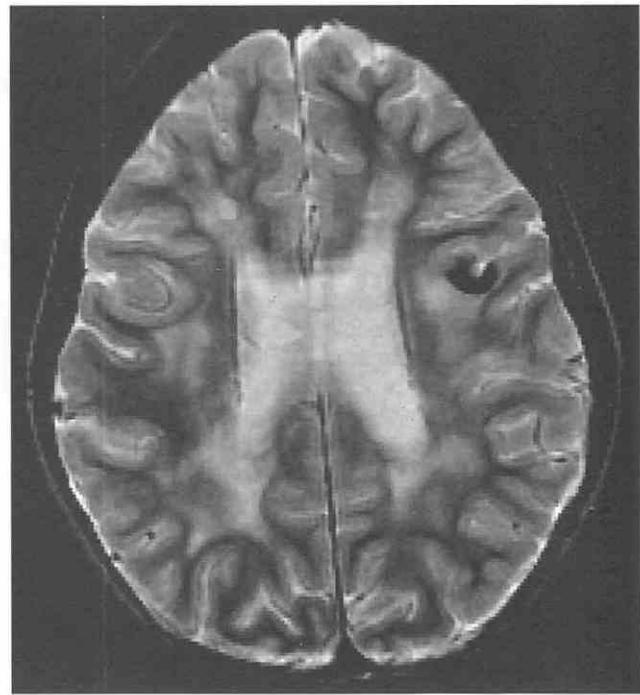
Diffuse necrotizing leukoencephalopathy (DNL) in a 20-year-old man with acute lymphoblastic leukemia several years after intrathecal methotrexate therapy and craniospinal irradiation. This T2-weighted axial MR image demonstrates widespread demyelination; there also is a focus of T2-weighted hypointensity in the left frontal deep cortex, indicating dystrophic calcification (mineralizing microangiopathy).
